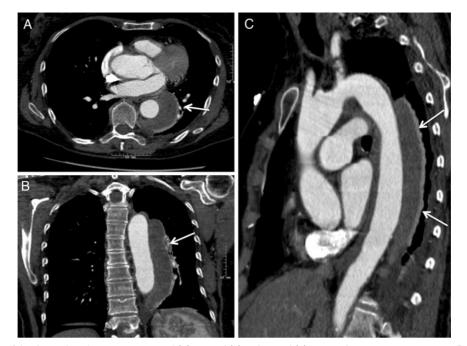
CT angiography of the descending thoracic aorta in axial (A), coronal (B) and sagittal (C) section demonstrating a periaortic fluid collection with contrast enhancement along the border (white arrows).
